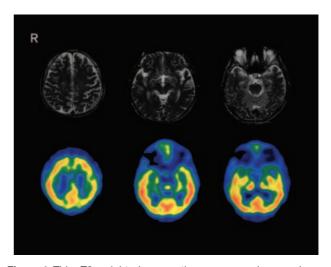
This T2-weighted magnetic resonance image shows slight atrophy of the bilateral medial frontal and anterior temporal lobes, and several small ischemic lesions in the subcortical areas. ⁹⁹TC-HMPAO SPECT shows a mild decrease in the cerebral blood flow in the atrophic regions and the bilateral medial temporal lobes. R indicates the right side of the brain.
